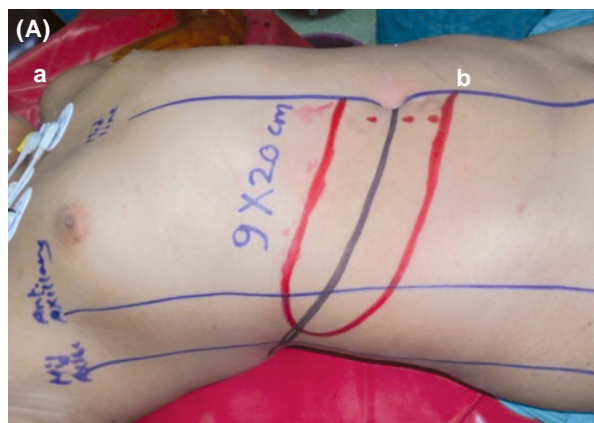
(A): Preoperative flap marking [extensions of the flap (9x20) and doppler U/S marking of perforators (red dots)], with the design of the flap on the axis that extends from the umbilicus towards the angle of scapula, (B): Primary closure of the donor area after flap dissection.
